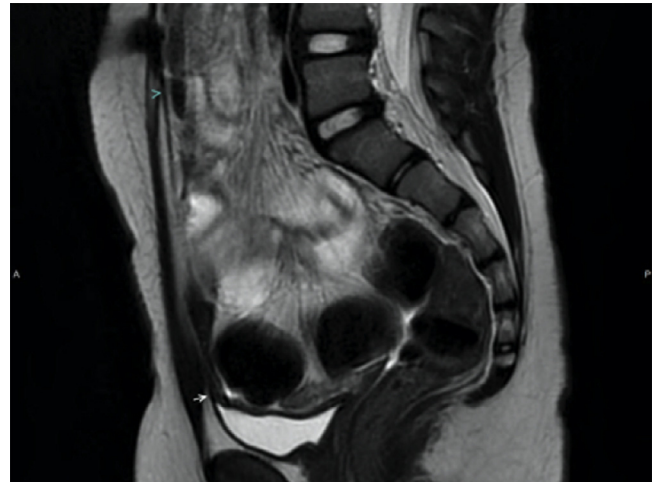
Multiple sagittal T2-weighted MRI imaging through the midline abdomen and pelvis demonstrates an anterosuperior outpouching within the bladder as demonstrated by the white arrows and arrowhead. The median umbilical ligament is identified with the blue arrowhead; distended large bowel prevents complete visualization of the umbilical ligament into the vesico-urachal diverticulum along a single sagittal image.
